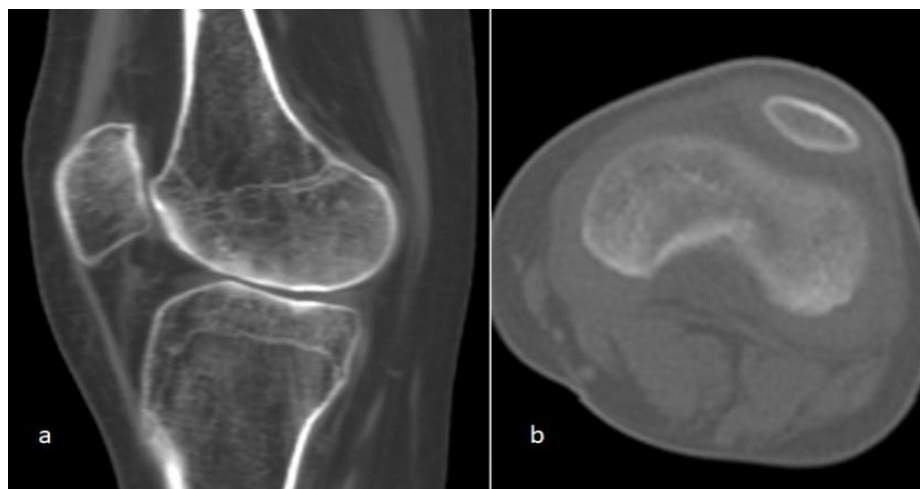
3D sagittal CT scan of the knee of a-17-years-old-boy with nail patella syndrome showed mild and painful flexion deformity of the knee associated with hypoplastic/fragmented and a dislocated patella on top of long term knee deformity and osteoporosis (a). The skyline view of the same patient at the age of 22 years showed progressive severe dysplasia and subluxation of the patellae associated with aplasia of the trochlear groove (b).
